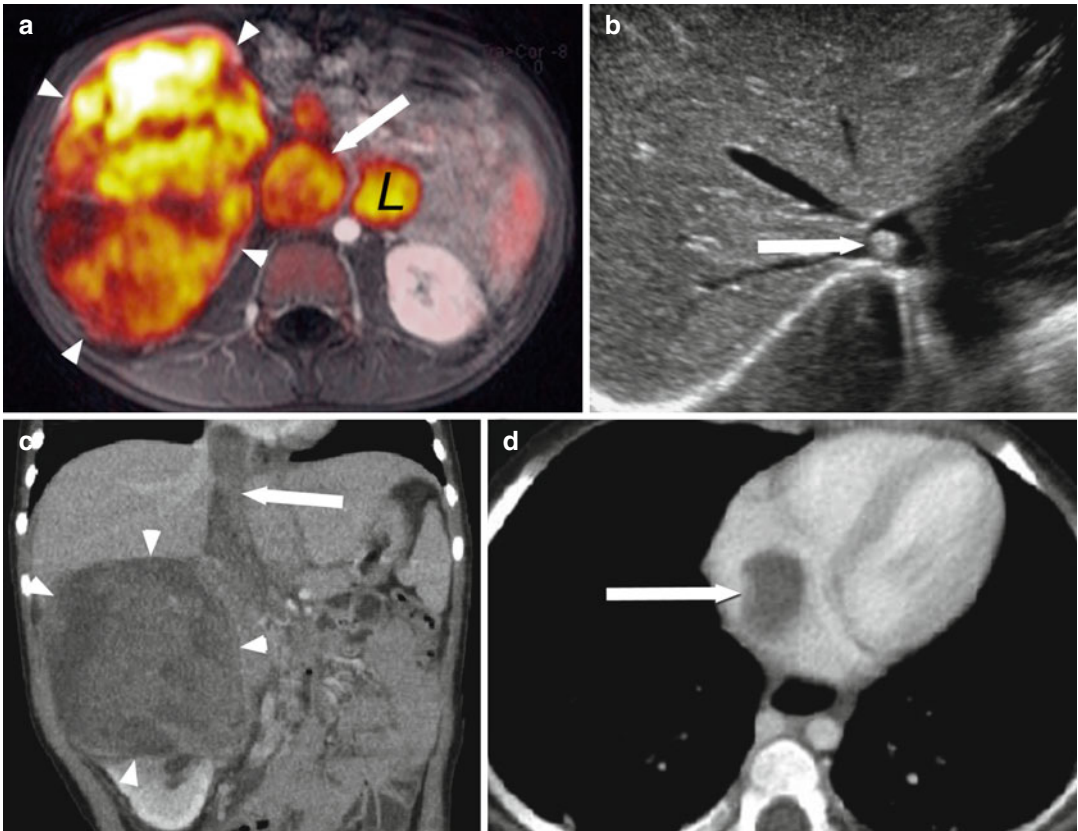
Venous invasion in three different patients with three different modalities. (a) MRI with diffusion-weighted (red scale) overlay on T1-weighted post-contrast (grayscale) sequence demonstrates a large right-sided renal tumor (arrowheads), large lymph node mass (L), and tumor thrombus in the inferior vena cava (arrow). (b) Ultrasound is very sensitive for small thrombi; a fine
